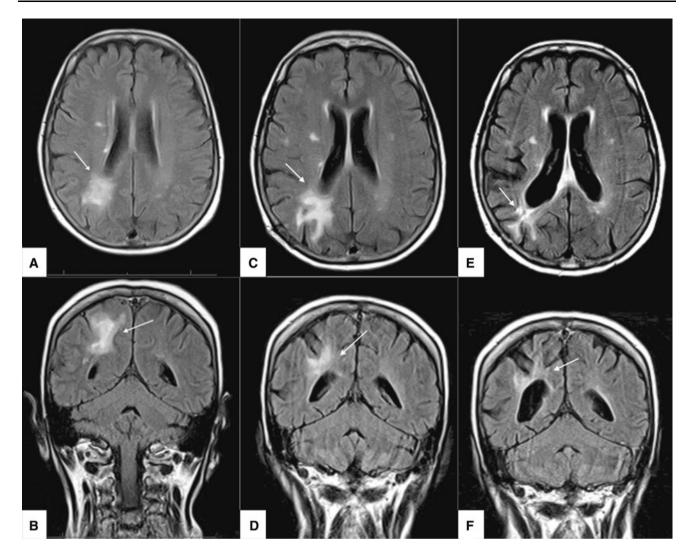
a, b Magnetic resonance imaging scan of the brain at the time of presentation with progressive multifocal leukoencephalopathy. The axial (panel a) and coronal FLAIR images (panel b) demonstrated multiple hyperintense lesions with the largest one visualized in the right posterior parietal lobe (*arrow*). The lesions did not demonstrate restriction on diffusion weighted imaging and were hypointense on T1 weighted images (not shown). A small amount of peripheral enhancement was demonstrated after administration of gadolinium.
